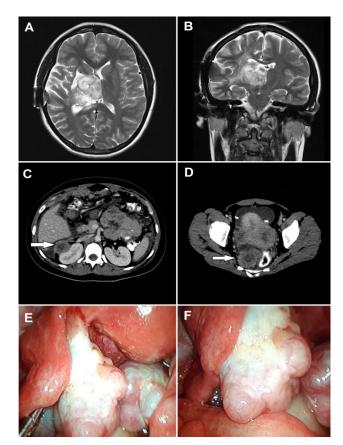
A) Axial T2-weighted brain MRI that evidences a right thalamic high signal lesion that compromises the third ventricle; B) Coronal Axial T2-weighted brain MRI that evidences a right thalamic high signal lesion that compromises the third ventricle with vasogenic edema surrounding the mass; C) Axial abdominal CT-scan that evidences a low-density nodular lesion anterior to the right kidney; D) Axial pelvic CT-scan that shows the distal end of the VPS catheter and multiple nodular lesions of the ovaries; E-F) Laparoscopic image that shows nodular lesions in the ovaries.
